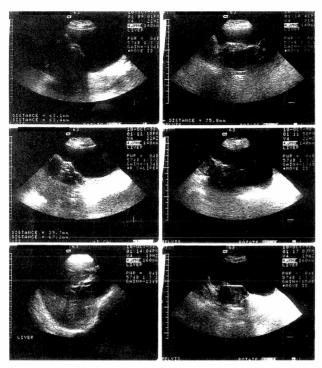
Ultrasound scan showing a 6.5x6.5x7 cm mass in the place of the uterus.
